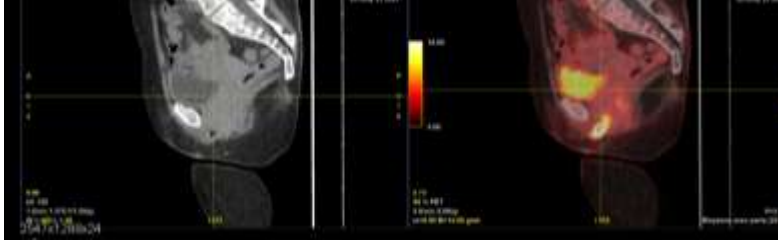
PET-CT findings showing the initial involvement of the vulva (sagittal view).
